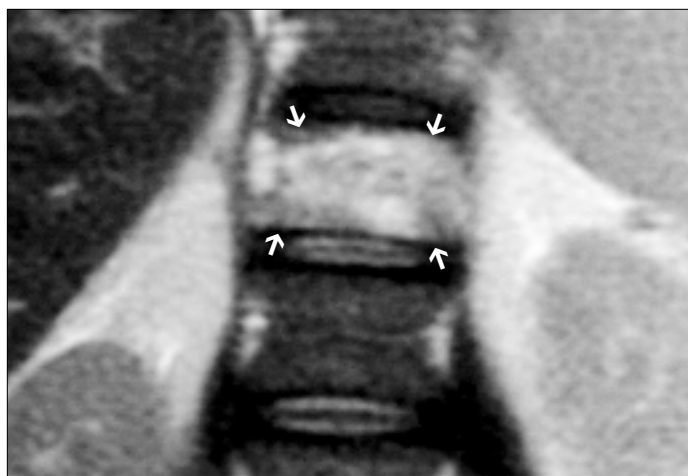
Coronal T2-weighted magnetic resonance (MR) image shows increased signal intensity in the T12 vertebral body (arrows).
